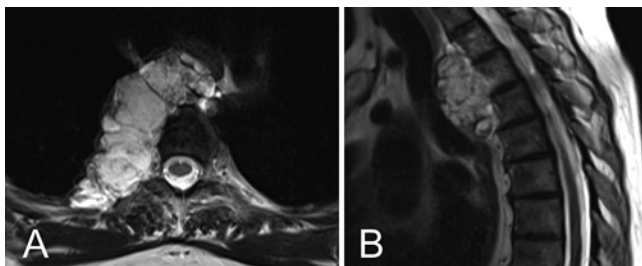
Axial (A) and sagittal (B) T2-weighted MR images of a T2–5 chordoma.
